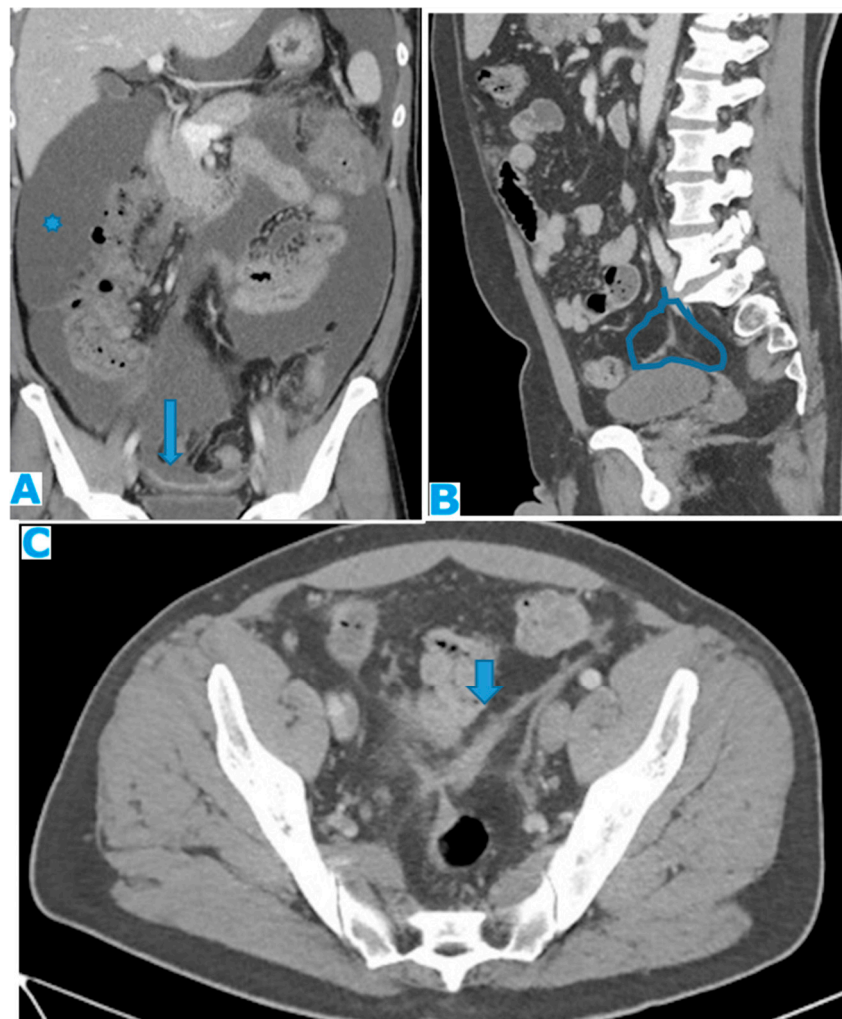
CE-CT Coronal MPR (A). PC from colon carcinoma: Observe how the parietal peritoneum does not reach the pelvis floor. Ascites (*). Deposits within the pelvic reflexion (arrow). Sagittal MPR (B), axial CE-CT (C). PC from adenocarcinoma of the appendix: Irregularly thickened peritoneal
